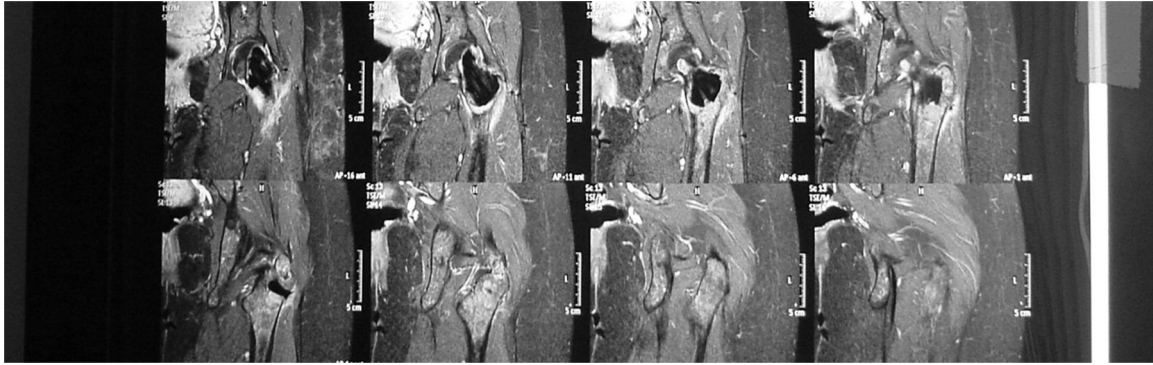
Magnetic resonance imaging of the left hip in sagittal plane in T2, showing GCT recurrence one year after the first surgery.
